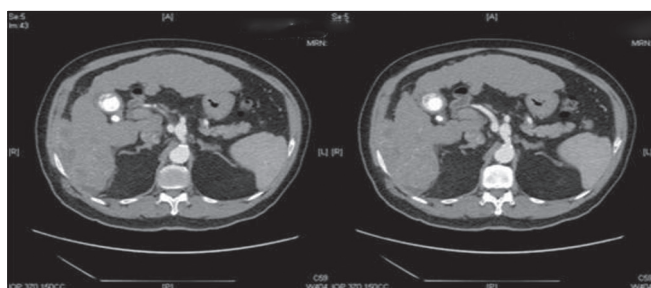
Computed tomography scan in arterial phase showing a segment VI heterogeneously enhancing mass with invasion to the postero-lateral chest wall
